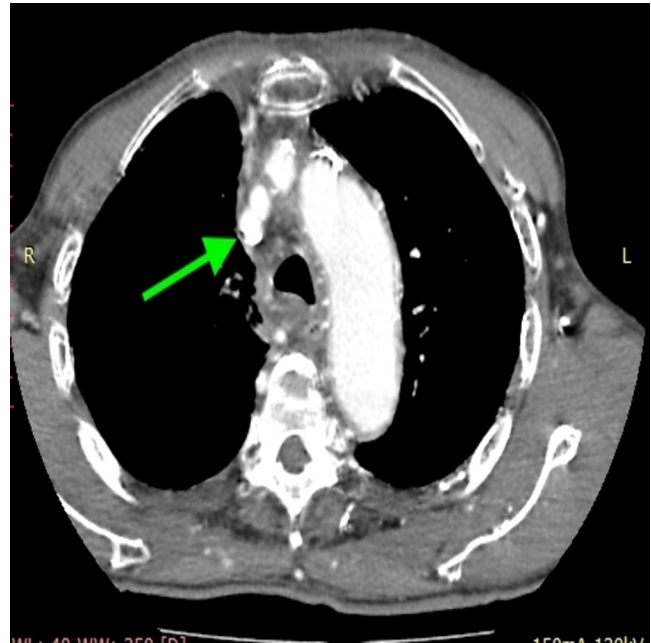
Non-contrast CT axial image of patient shows patent superior vena cava just distal to the confluence and just proximal to the mass (arrow)
